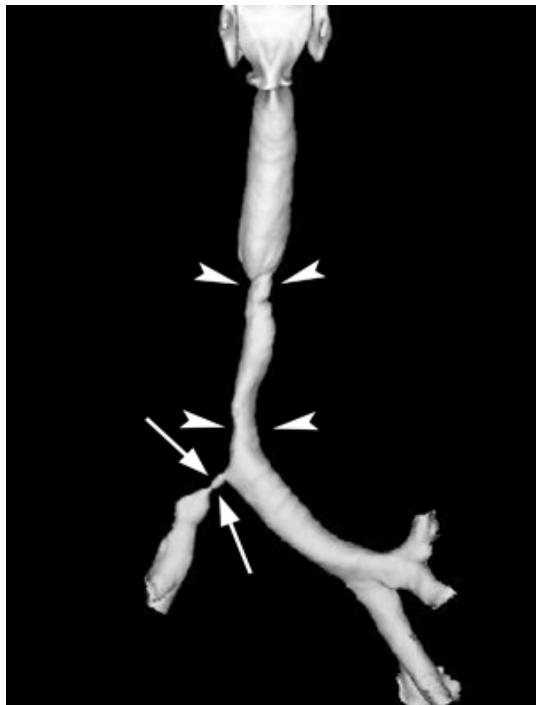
Anteroposterior view of three-dimensional (3D) reconstruction CT shows a 6-cm-long tracheal stenosis from mid-trachea to carina and a 1.5-cm-long right main bronchial stenosis.
